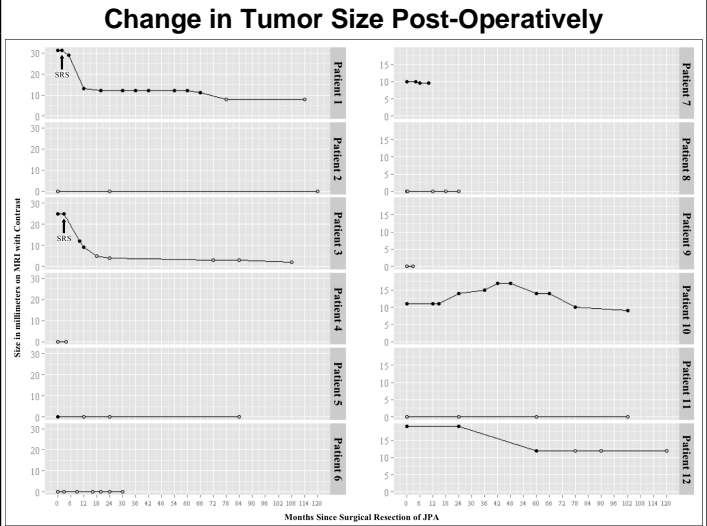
Change in maximal diameter on magnetic resonance imaging (MRI) with contrast after most recent surgical resection in months. Time 0 months is the immediate post-operative MRI. Data points are shaded black if tumor/operative site was enhancing or shaded grey if non-enhancing. SRS = stereotactic radiosurgery.
